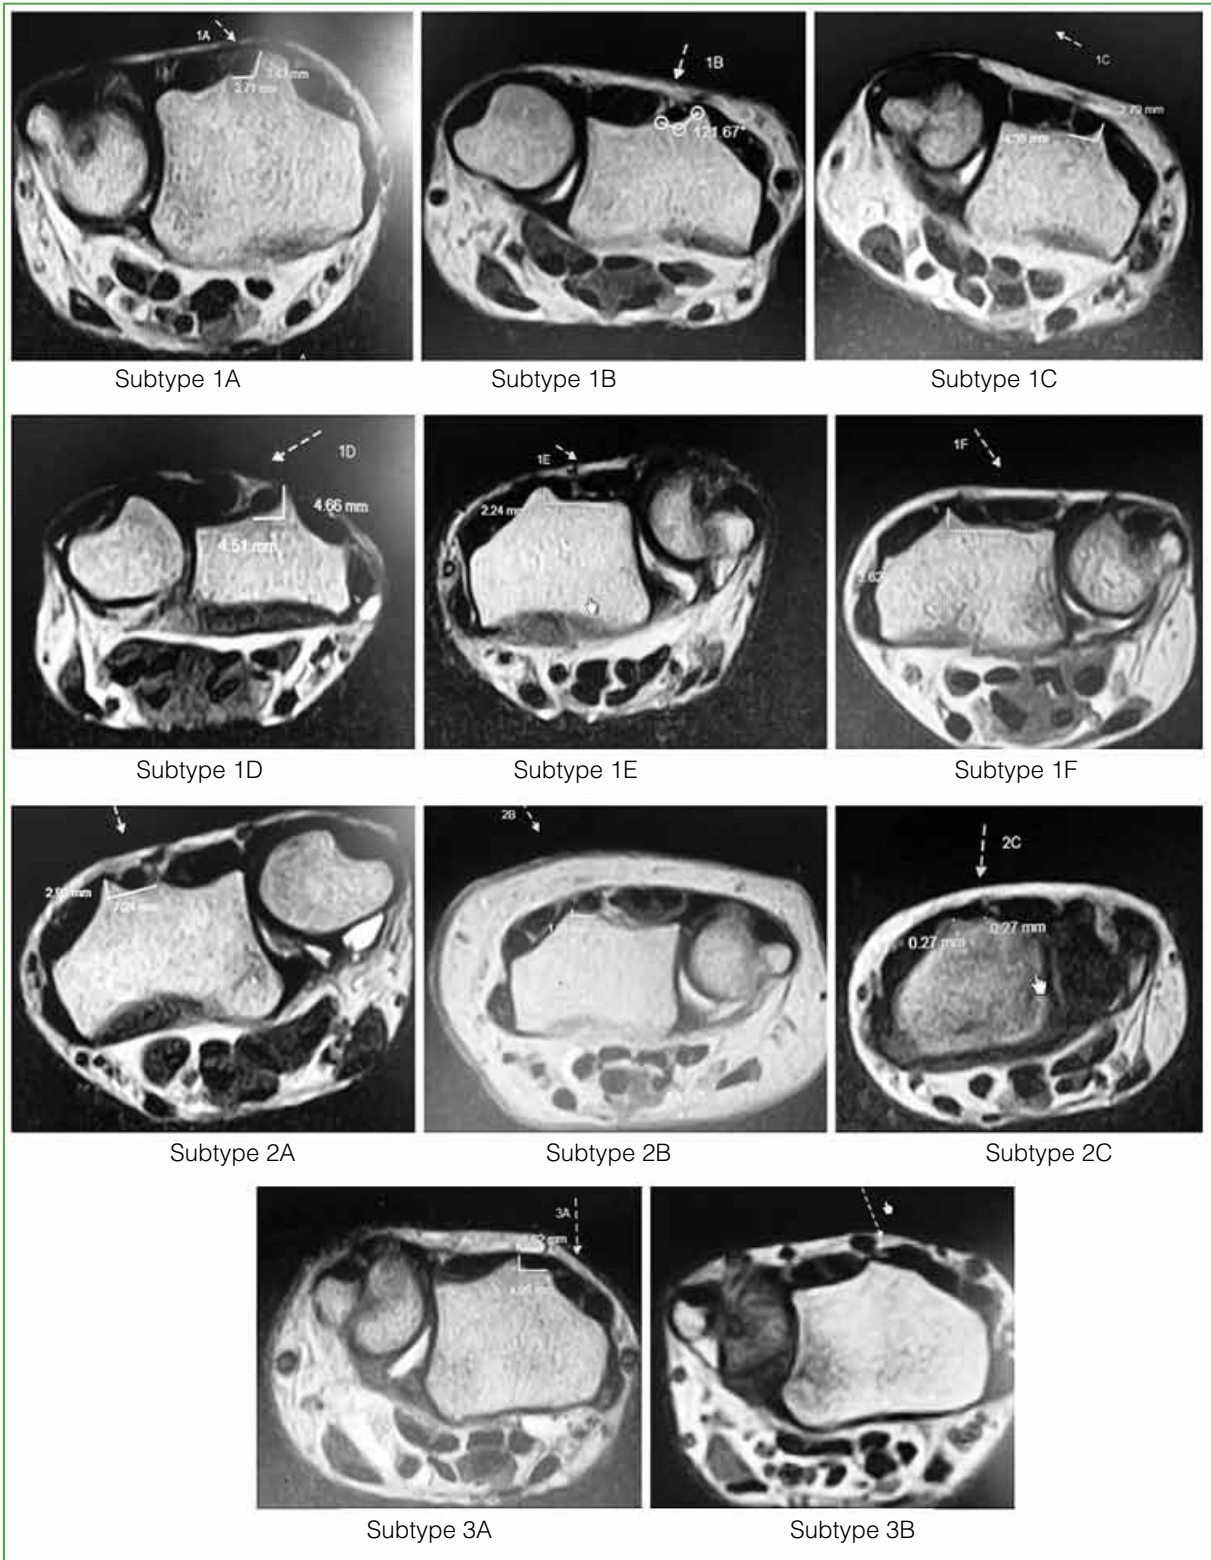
Magnetic resonance imaging of the different types of Lister's tubercle.
